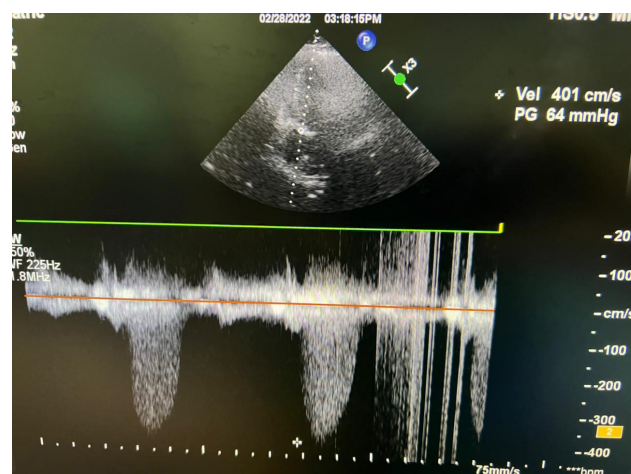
Echocardiogram. Pressure gradient across aortic valve before TAVI
